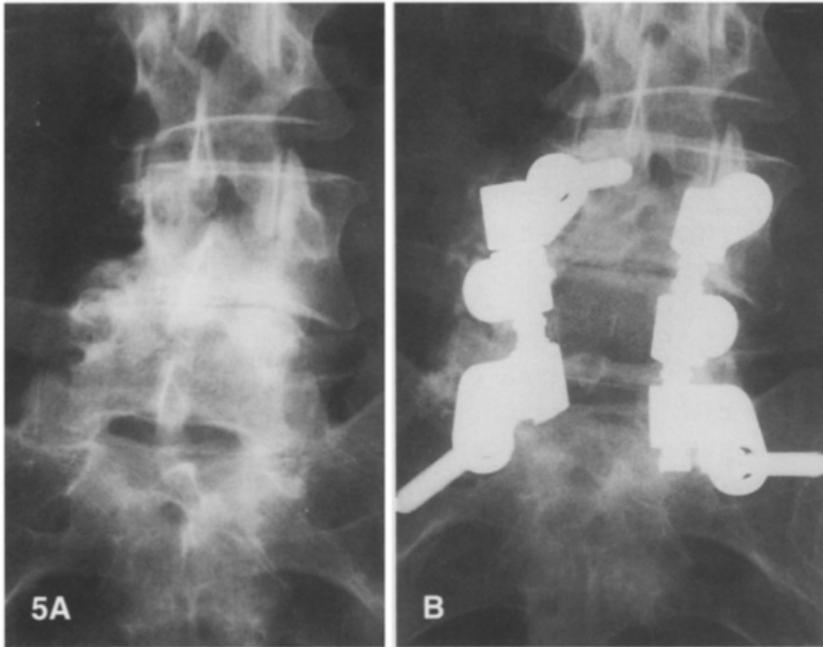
A. Spondylolysis and spondylolisthesis at the L5-S1 level: preoperative roentgenogram. B. Postoperative plain radiograph showing L4-S 1 arthrodesis with CUN instrumentation. The L4 level was included in the arthrodesis to achieve a more rigid fixation.
